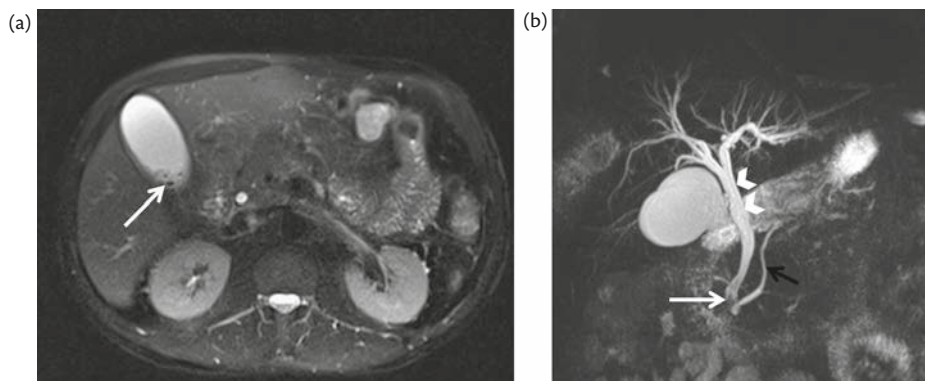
(a) Axial T2 MRI through the gall bladder. Multiple tiny rounded areas of signal loss represent gall bladder calculi (white arrow). (b) MIP Slab MRCP shows the whole biliary tree with mildly dilated common bile duct (arrowheads) and intrahepatic channels, with a calculus in the distal common bile duct (white arrow). Pancreatic duct appears normal (black arrow).
